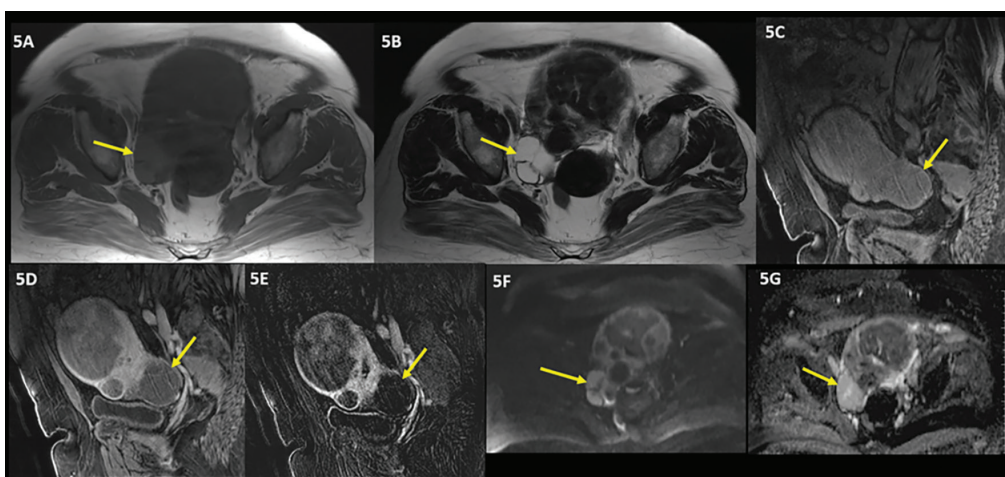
A 67-year-old woman referring for cervical smear. In the right ovary, a lesion sized 46x40x45 mm, slightly hyperintense compared to the striated muscle in T1-weighted (T1W) axial (Figure 5A), fatsat T1W (Figure 5C arrow), markedly hyperintense in T2-weighted axial (Figure 5B), and multiloculated cystic, was observed. In the post-contrast series, a slightly contrasting cystic lesion was observed on only one wall (Figure 5D arrow and subtraction Figure 5E arrow), and a non-diffusion-restricting cystic lesion was observed in diffusion-weighted imagings (Figures 5F and 5G) (proven by biopsy cystadenofibroma)
